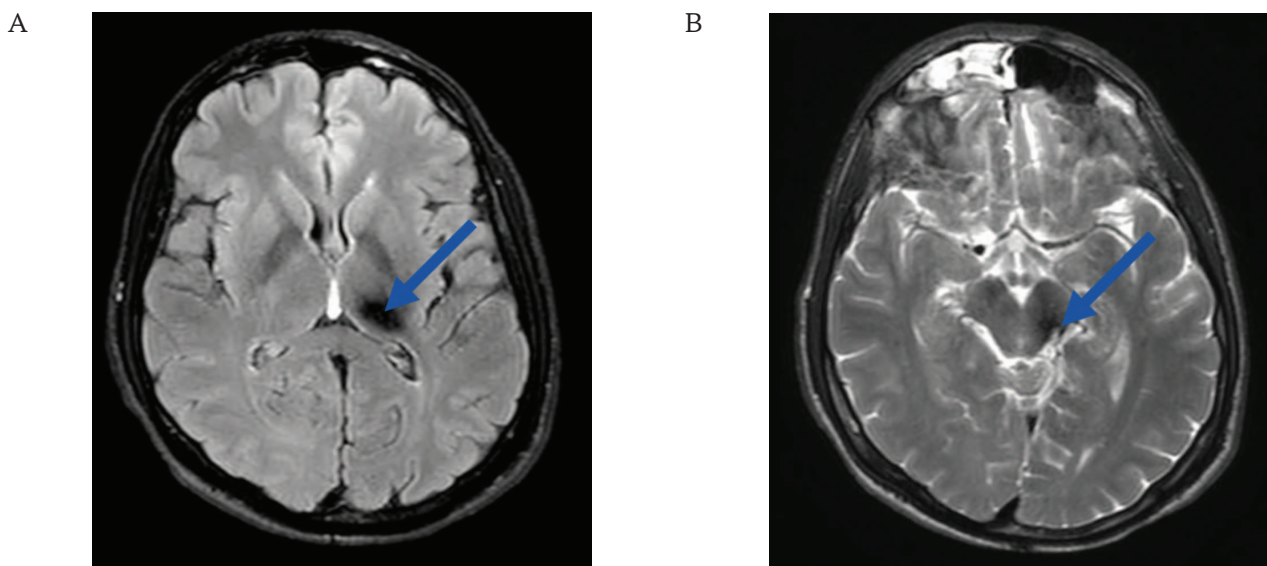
Magnetic resonance imaging of the brain of a 38-year-old patient 9 months after resection of a cavernous malformation in the dorsal part of the left peduncle of the midbrain (February 18, 2025)
